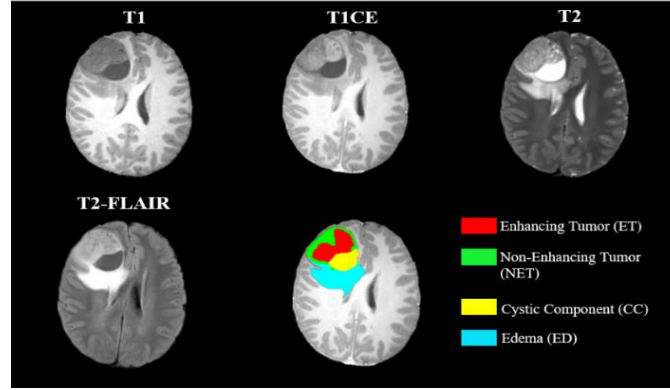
The four MRI sequences: here (a) T1-weighted (T1W); (b) contrast-enhanced T1-weighted (T1CE); (c) T2-weighted (T2W); (d) T2-weighted Fluid-Attenuated Inversion Recovery (T2-FLAIR); and (e) tumor subregion labels, where enhancing tumor (ET) is shown in red, the non-enhancing tumor (NET) in green, the cystic component (CC) in yellow, and the peritumoral edema (ED) in blue.
